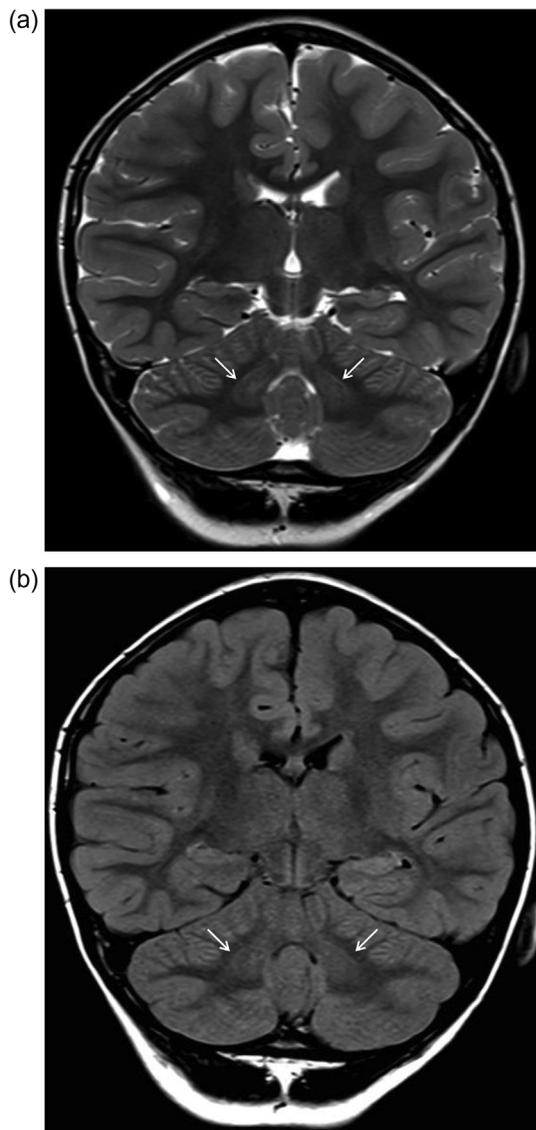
Brain MRI of Patient 1.4: Coronal T2 (A) and FLAIR (B) show bilateral symmetric hyperintensity of the dentate nuclei (arrows).
